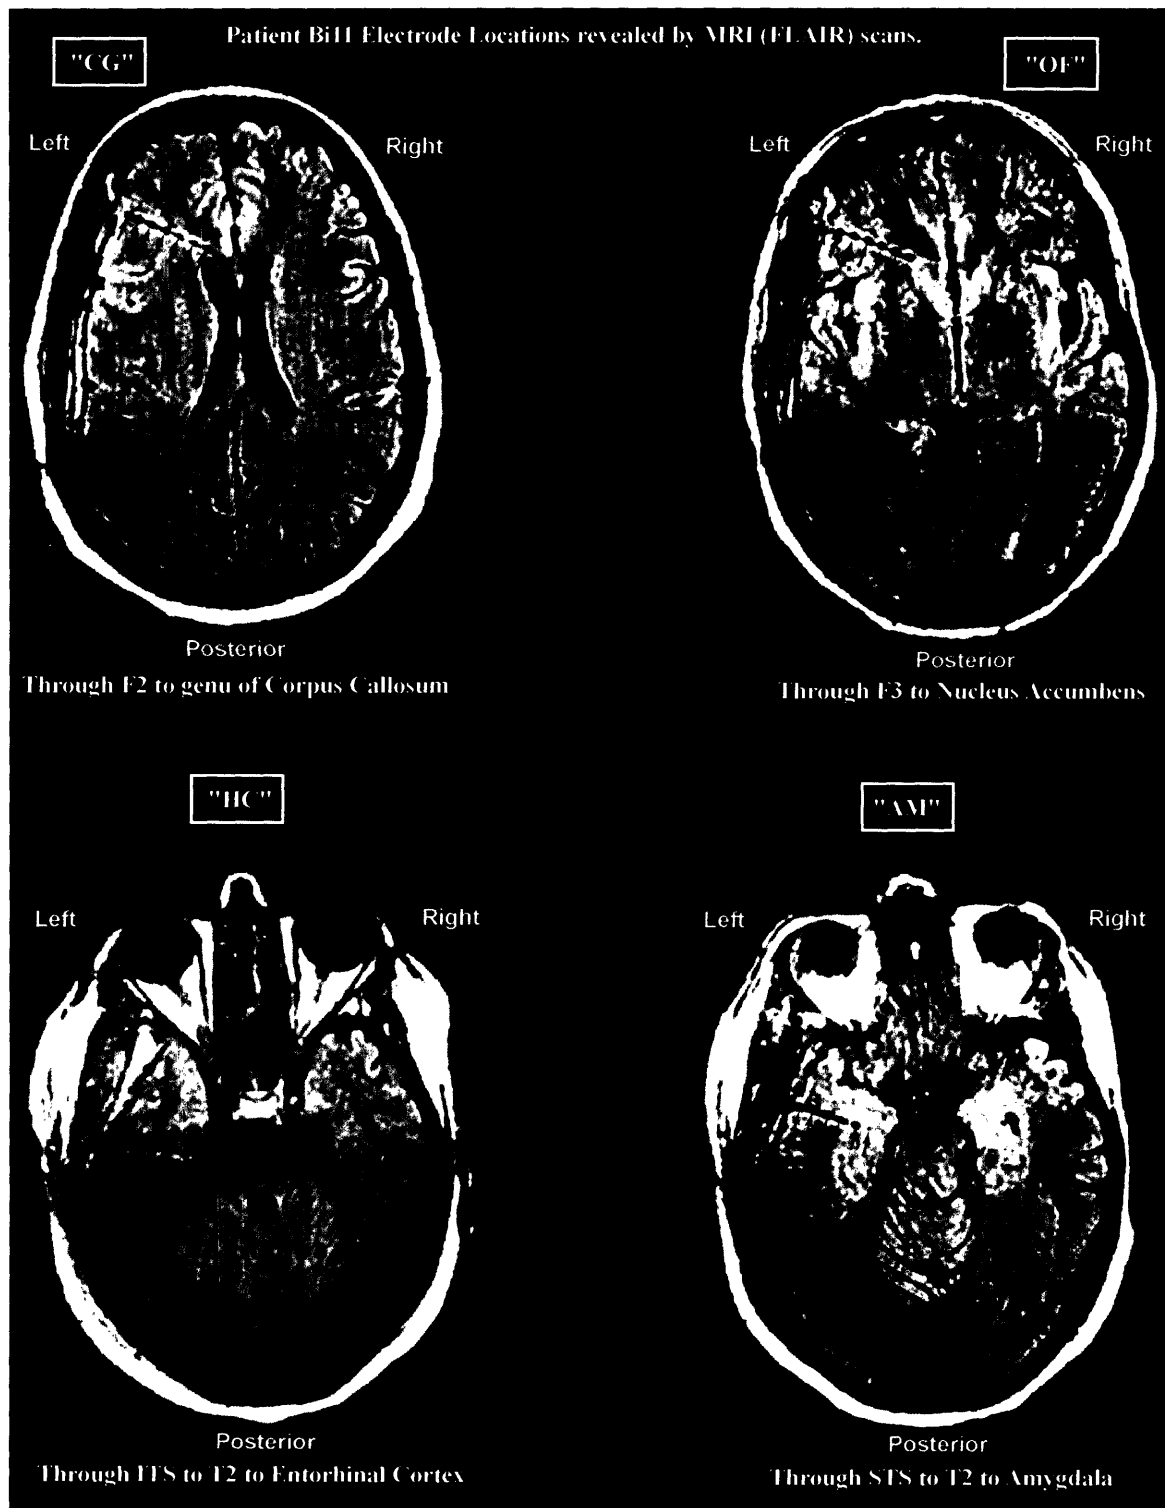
Trajectories of macroelectrodes visualized in clinical MRI scans of patient BI-11.
